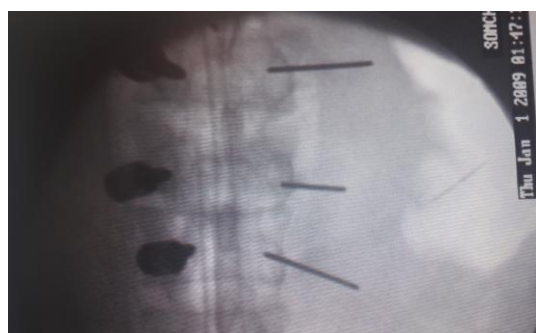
(b): Peroperative x-ray shows screw introduction in pedicle
